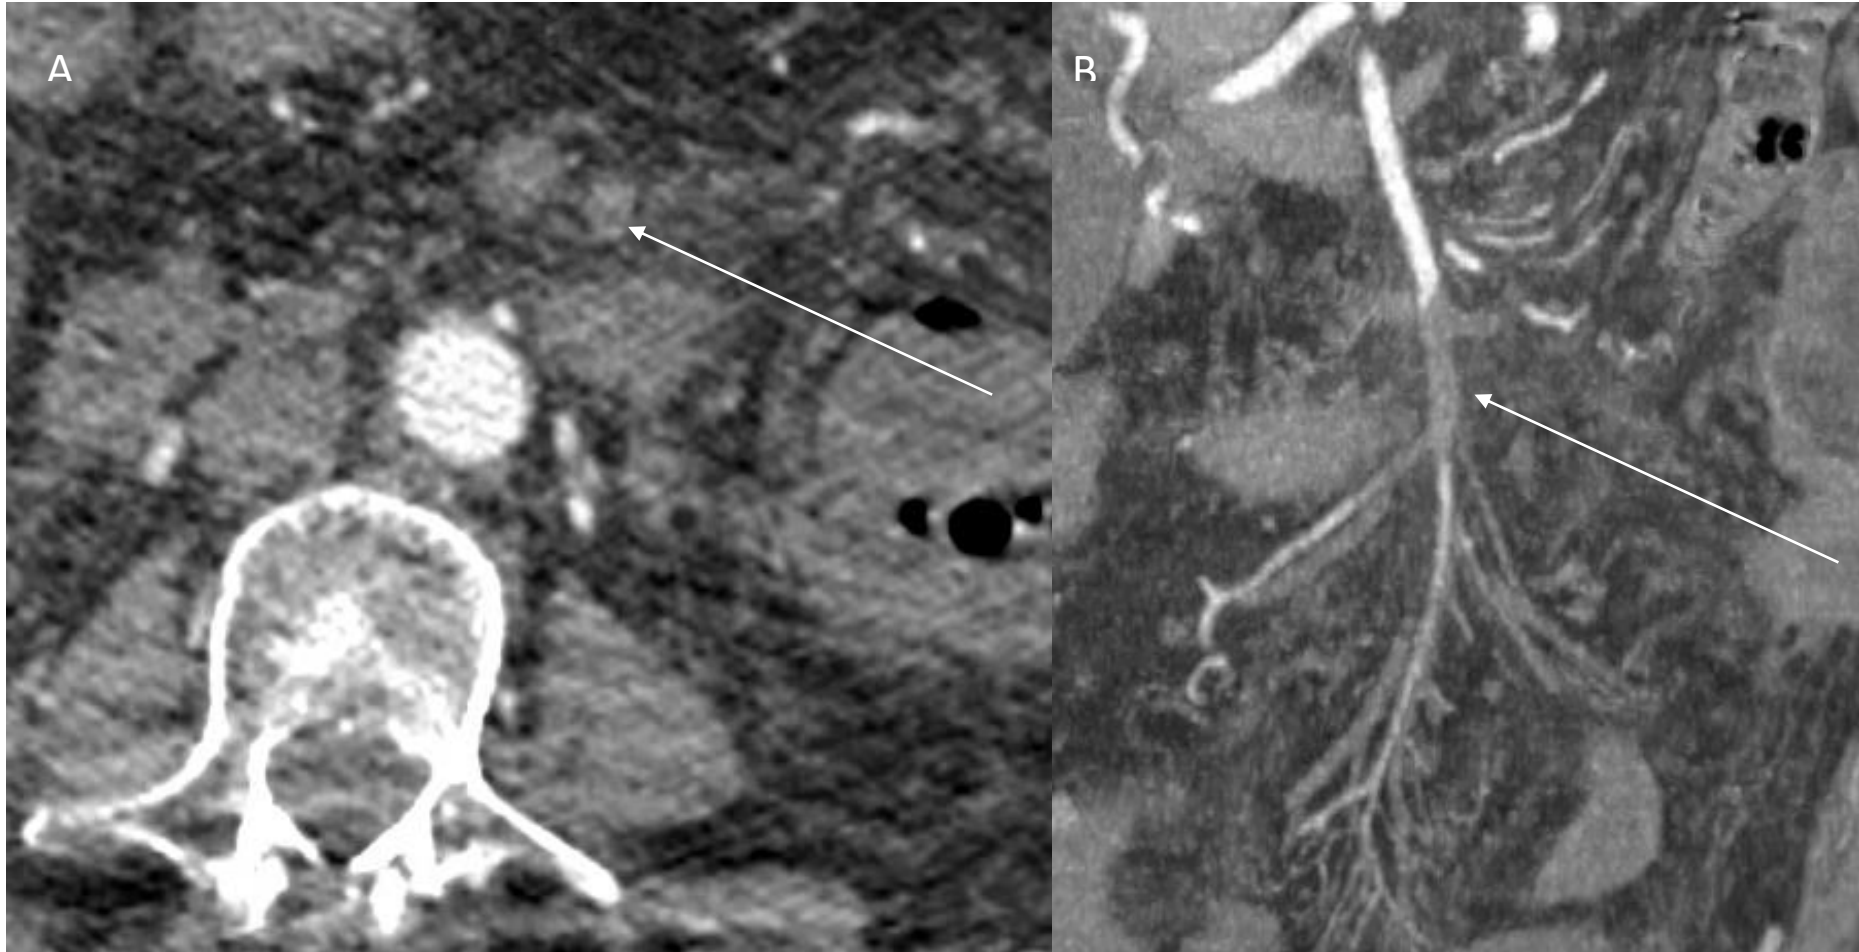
Abdominal CT-scan of a 80 years old patient with AMI showing an complete occlusion of the S2 and S3 segment of the SMA (arrow) : (A) axial view and (B) coronal view
